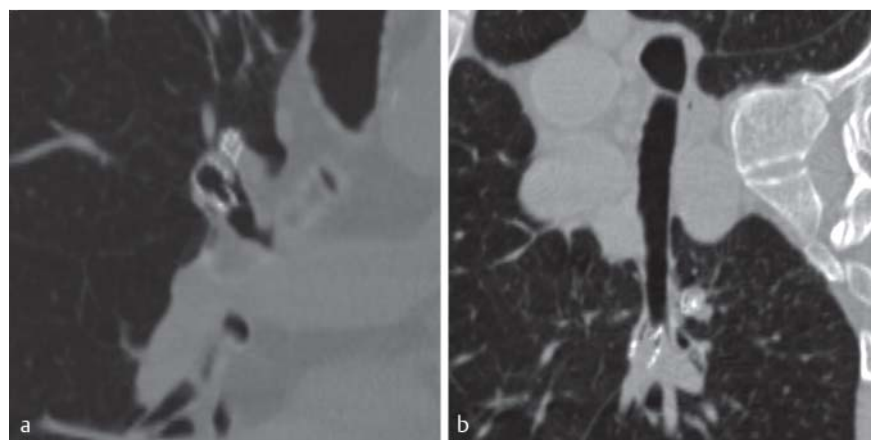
a shows a multiplanar CT reconstruction of a properly resting endobronchial valve in the right superior lobe of a 63-year old patient. b shows a valve properly positioned in the right superior lobe of a 59-year old patient, yet displaced by mucus. Because EBV can allow mucus to pass, this image does not necessarily indicate valve dysfunction. In this case, however, bronchoscopy confirmed a loss of function, and the valve was replaced.
